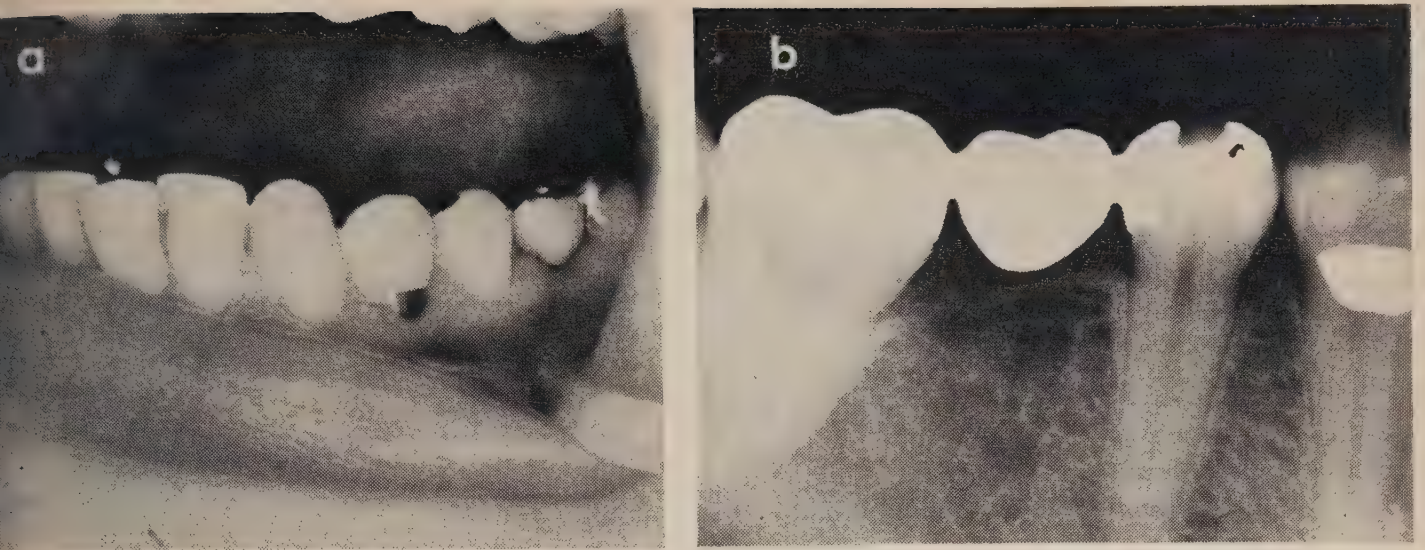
(a) Intra-oral photograph of the left quadrant bridge in place. A class 5 gold foil restoration had been placed in the bicuspid during the initial pre-operative treatment. (b) Radiograph showing the bridge in place. The pontic is in light contact with tissue and suitable embrasures facilitate home care procedures. The mesial surface of the anterior abutment was not included due to an ideal contact relationship, low caries susceptibility and excellent home care co-operation.
